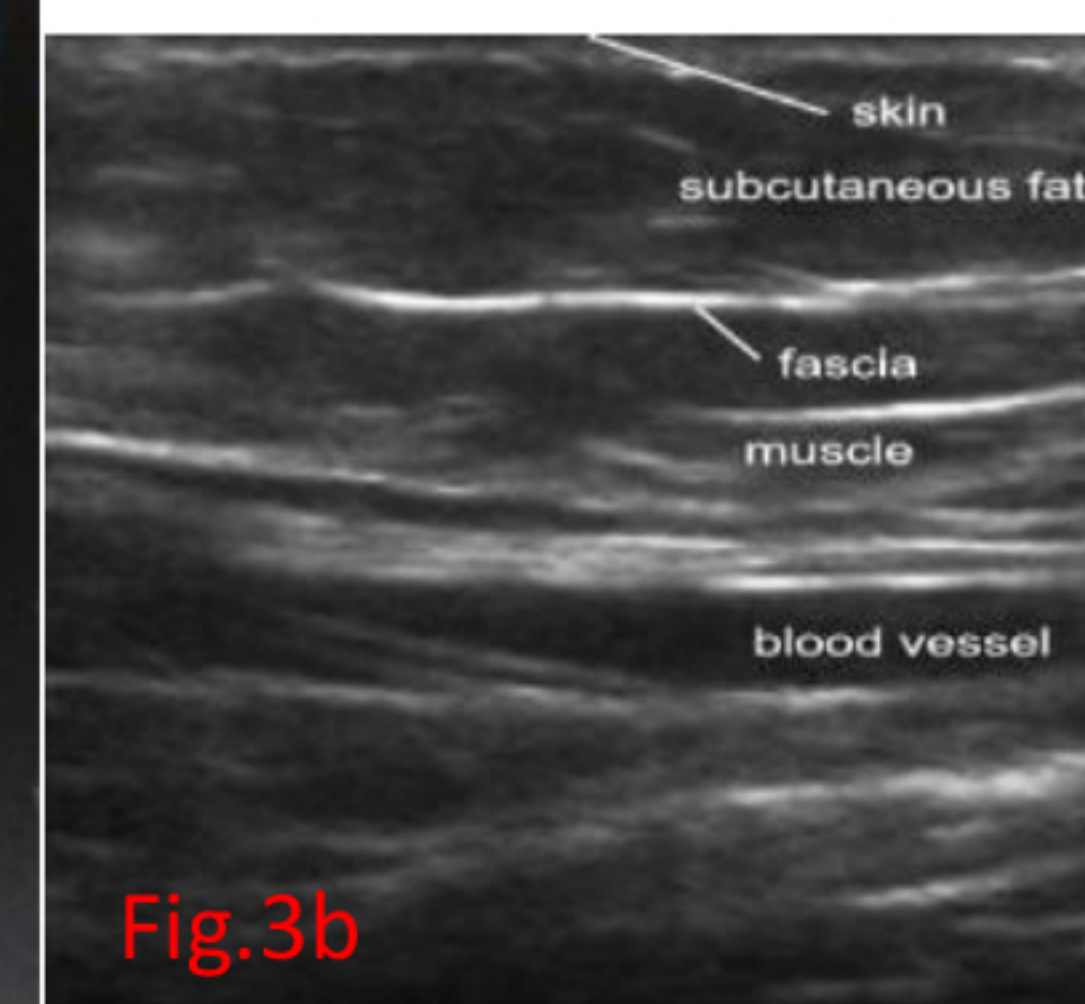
Site of swelling - heterogenous area; Fig.3b: represents ultrasonographic soft tissue impression of a normal area
